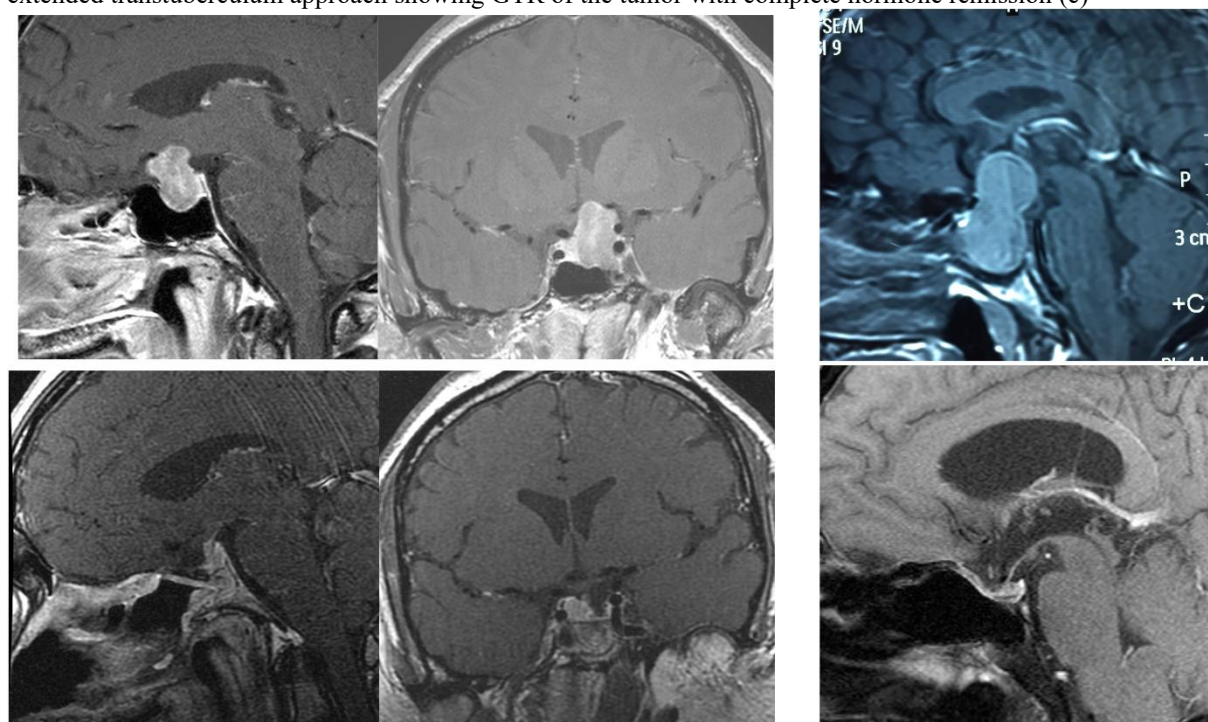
Examples of management of fibrous adenomas in our series. Case 1(a): Preoperative sagittal (left) and Coronal MRI (right) showing pituitary adenoma extending into suprasellar space and abutting both anterior cerebral arteries, the tumor was very fibrous. (b) Postoperative sagittal (left) and Coronal MRI (right) after EETA showing gross total resection of the tumor. Case 2 (c): Preoperative sagittal MRI showing dumbbell shaped pituitary adenoma extending into suprasellar space, the tumor was very firm. (d) Postoperative sagittal MRI after EETA showing gross total resection of the tumor.
